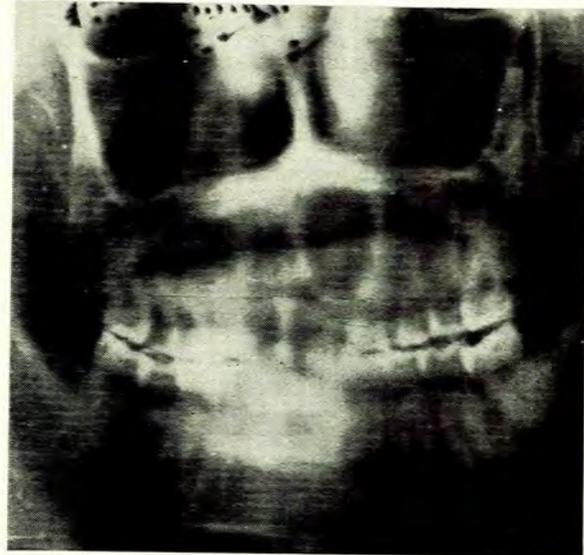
Orthopantomograph of maxilla in case 5, showing a median palatine cyst.
